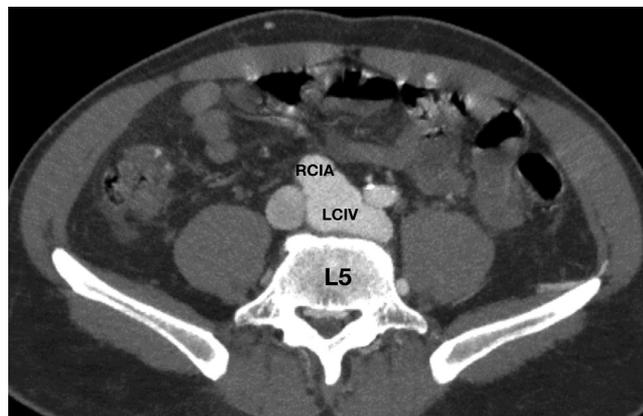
Computed tomographic angiography of the whole aorta. The fistula connects the right common iliac artery and the left common iliac vein in the axial view.
